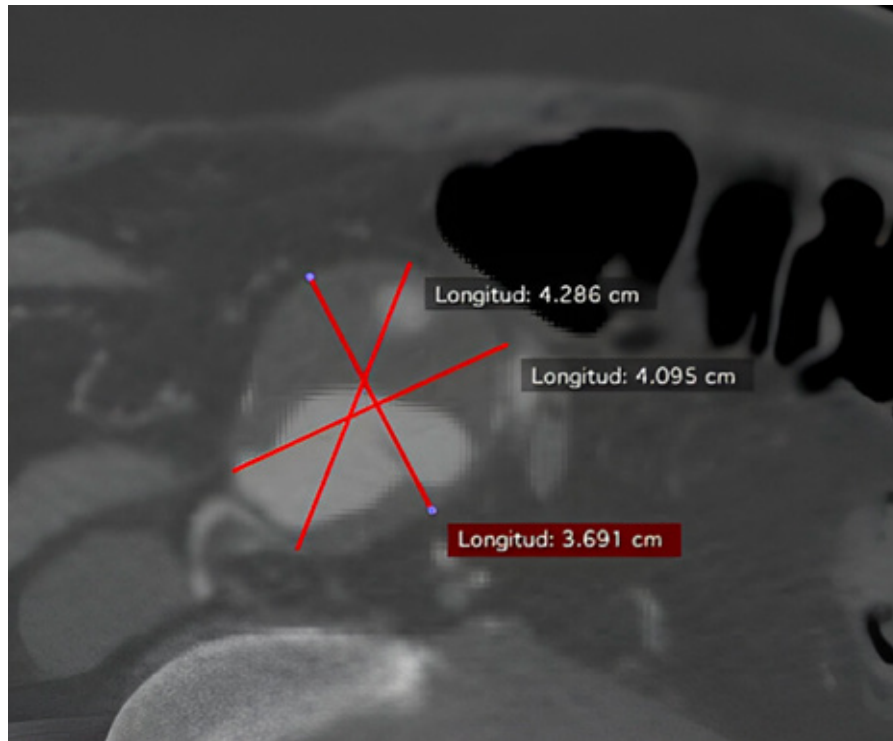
Abdominal computed tomography angiography: Axial view showing aneurysmal dilatation (red lines) with an intimal flap indicative of aortic dissection in the abdominal aorta.
